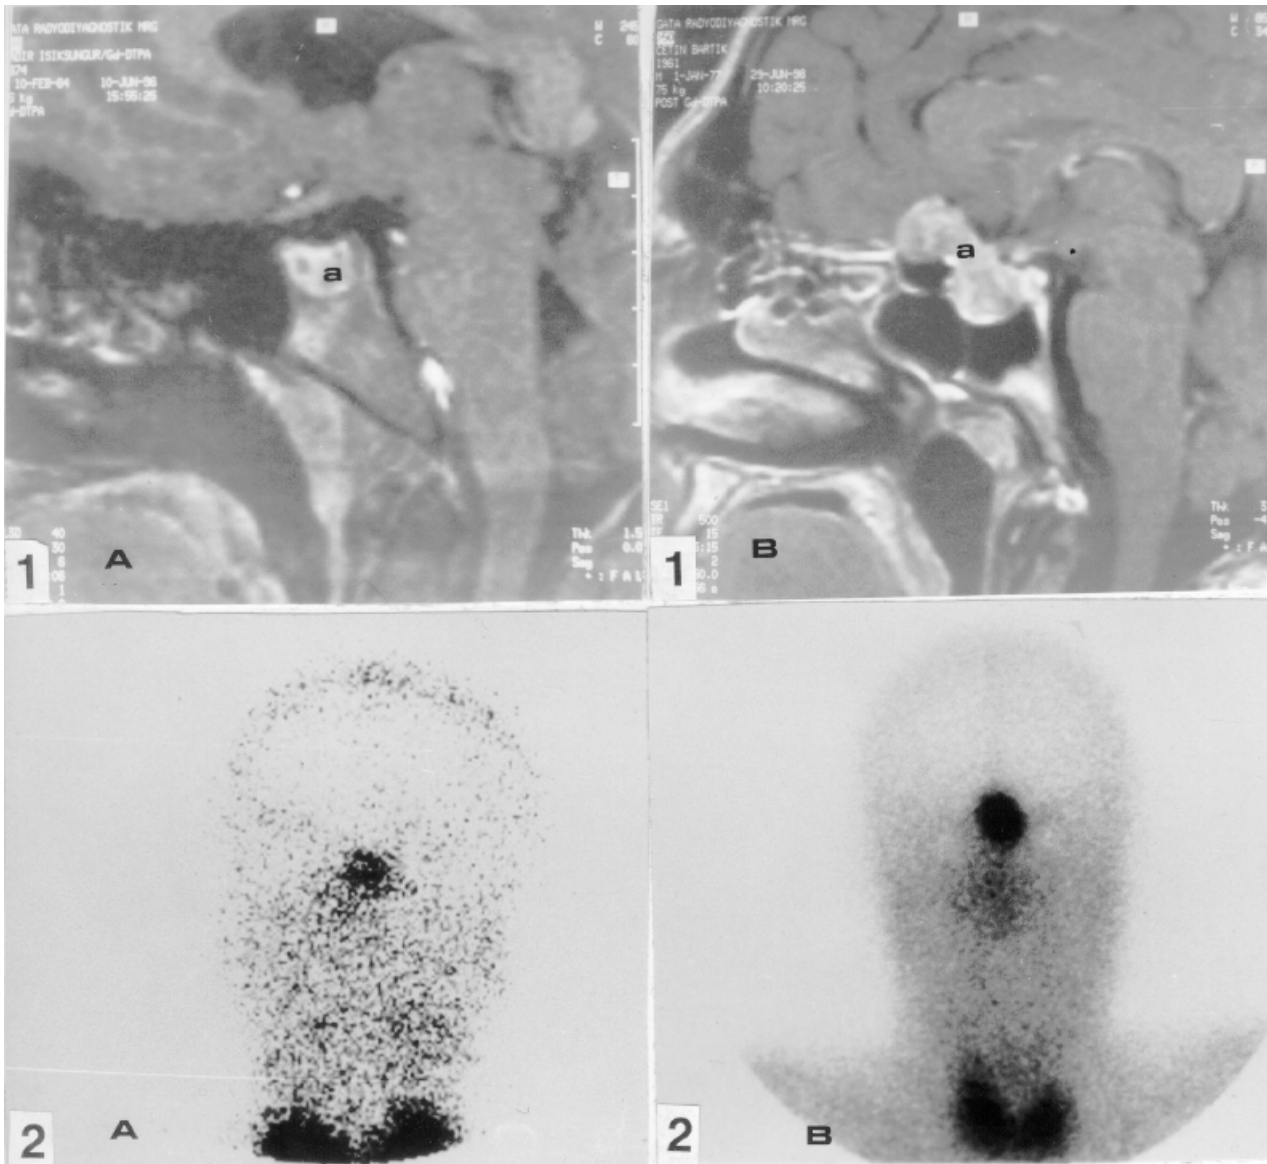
Baseline MRI's of the pituitary of the cases 1(A) and 2(B). A: adenoma
